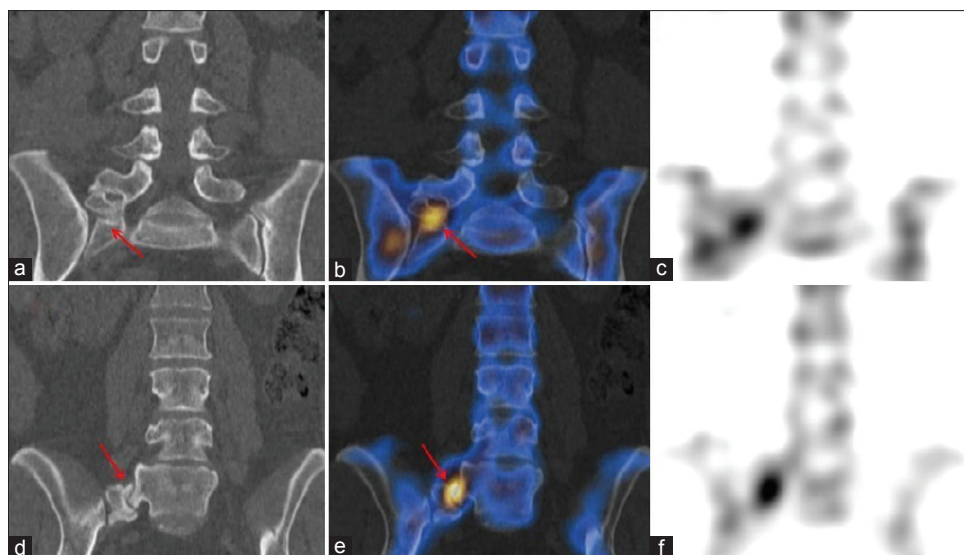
(a and d) coronal computed tomography; (b and e) fused single-photon emission tomography with computed tomography; (c and f) coronal single-photon emission tomography shows increased osteoblastic activity at both articulation sites (pseudoarthrosis) of the well-corticated bone with L5 (d and e arrows) and sacral ala (a and b arrows)
